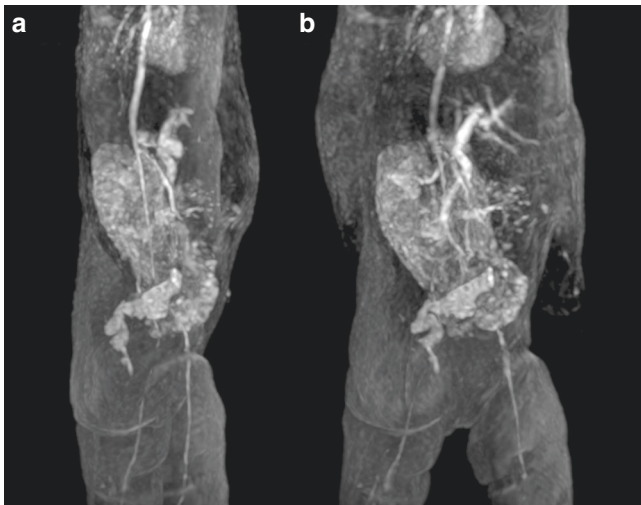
Diagnostic MRI of our 3-month-old patient's intestinal hemangioma prior to treatment. Abdominal T2-weighted MRI demonstrating extensive hemangioma involvement of the small bowel and mesentery with enlargement of the superior mesenteric artery and vein (a: transverse view; b: anteroposterior view).
